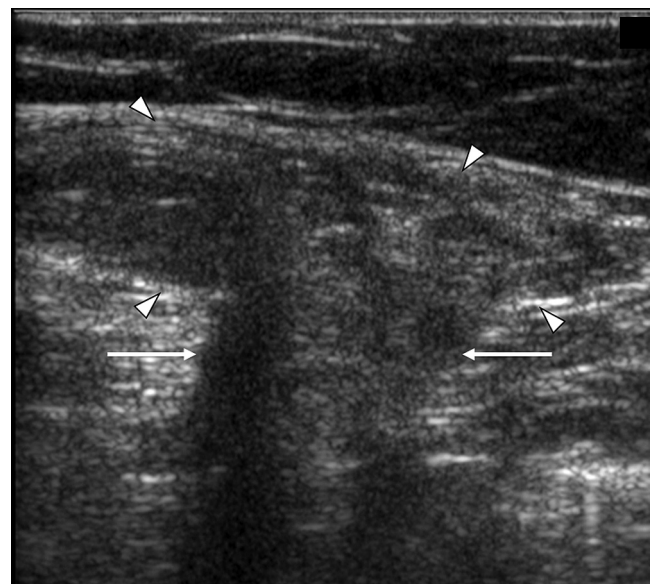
Umbilical hernia. Transverse sonogram of the umbilicus, showing a hernia (arrowheads) that contains mesentery passing through a defect in the umbilicus (arrows) to lie deep to the subcutaneous tissues.
